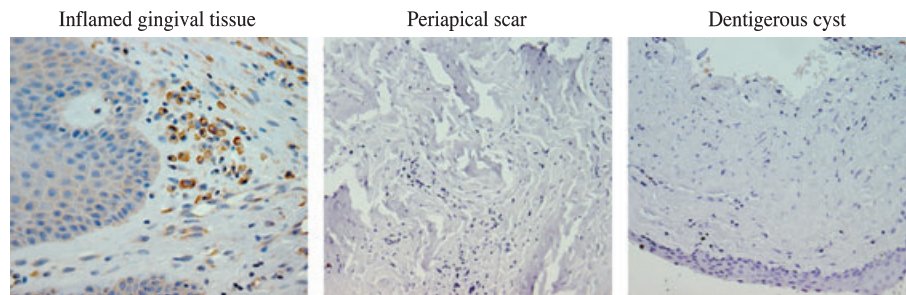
Expression of TLR2 by cells in the positive control; inflamed gingival tissue and no TLR2 expression in negative controls; periapical scar or dentigerous cyst ($\times 400$).
